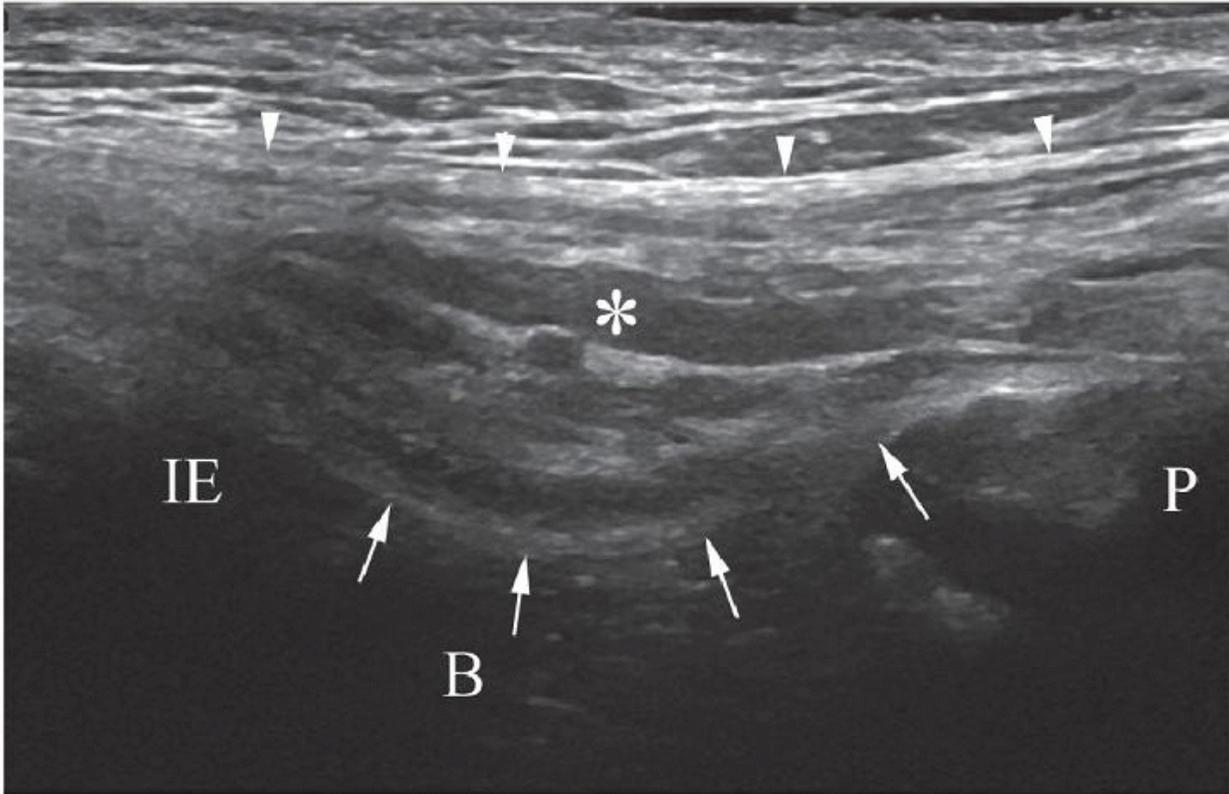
Normal inguinal canal (long axis). Longitudinal sonogram aligned parallel to the inguinal ligament demonstrates hyperechoic inguinal ligament (white arrowheads), inguinal canal contents (asterisk), inferior epigastric vessels (IE), and pubic tubercle (P). The hypoechoic area at the bottom of the picture represents bowel (B) deep to the posterior (deep) canal wall (arrows).
